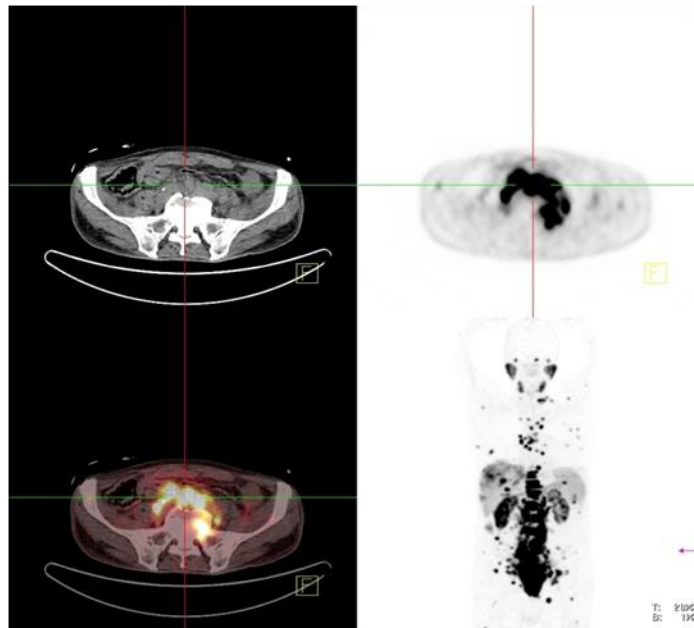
⁶⁸Ga-PSMA PET/CT scan, Skull top to Mid-Thigh
